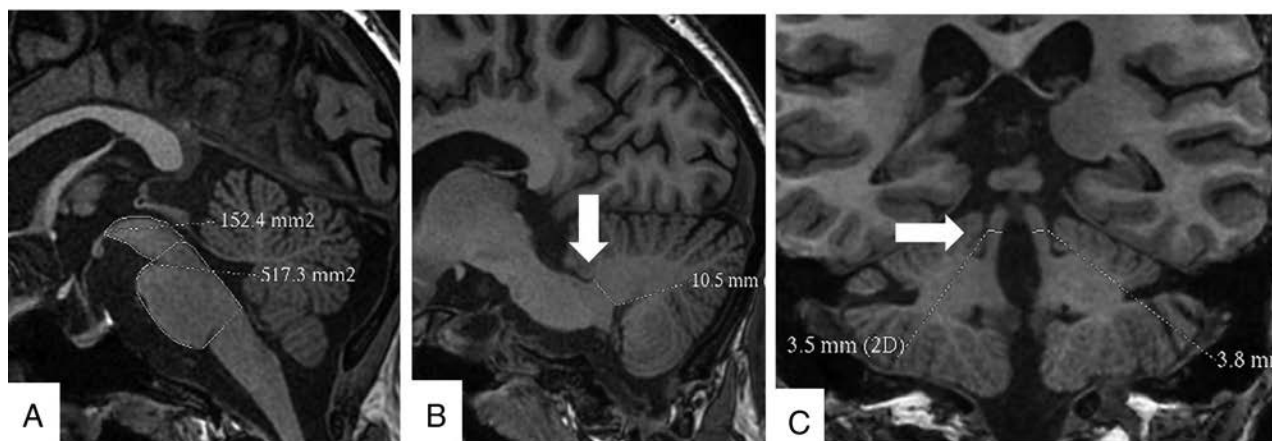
Cranial MR imaging in the BRAVO 3D sequence showing the protocol of measurement of the midbrain and pons areas (A), width of the middle cerebellar peduncle (B), and width of the superior cerebellar peduncle (C).
